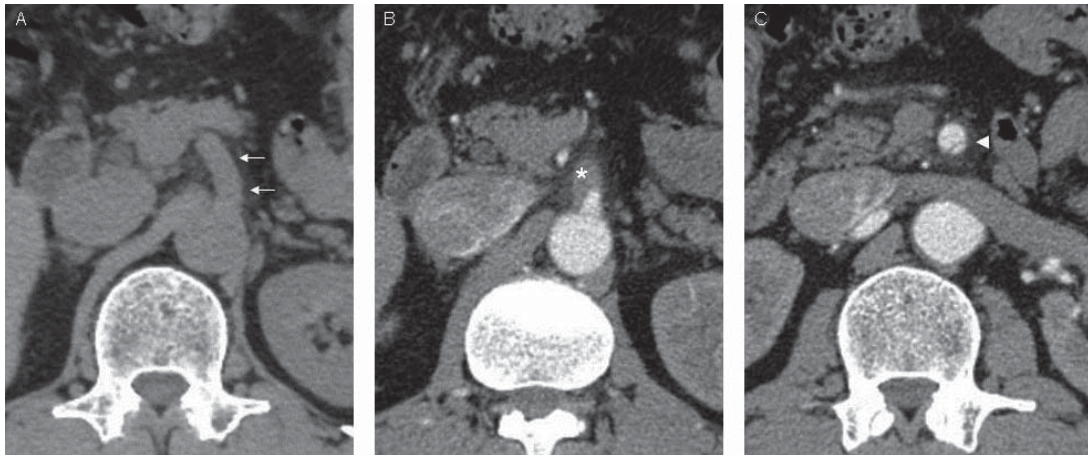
CT images of the abdomen
